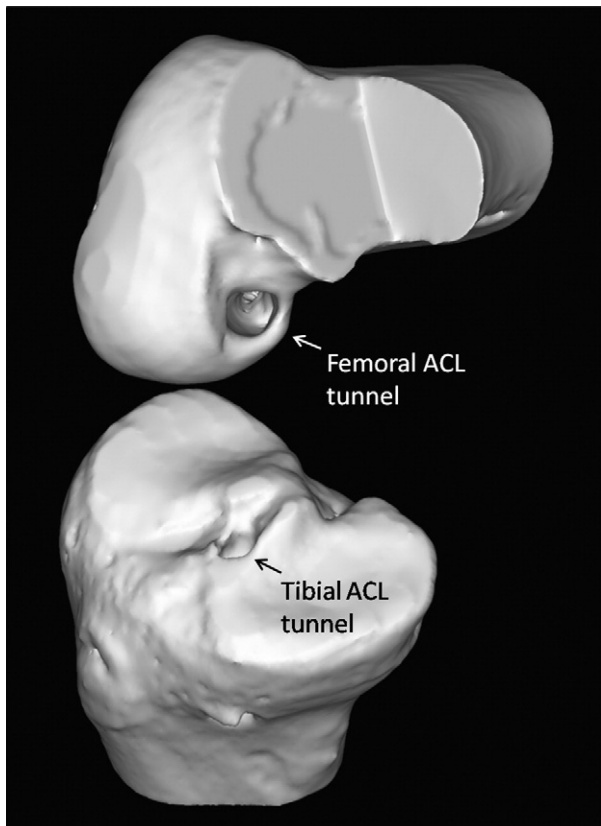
Three-dimensional reconstructed computed tomography scan of a right knee after anatomic single-bundle reconstruction. The medial femoral condyle is removed to show the whole lateral wall of the femoral intercondylar notch with the femoral tunnel.
